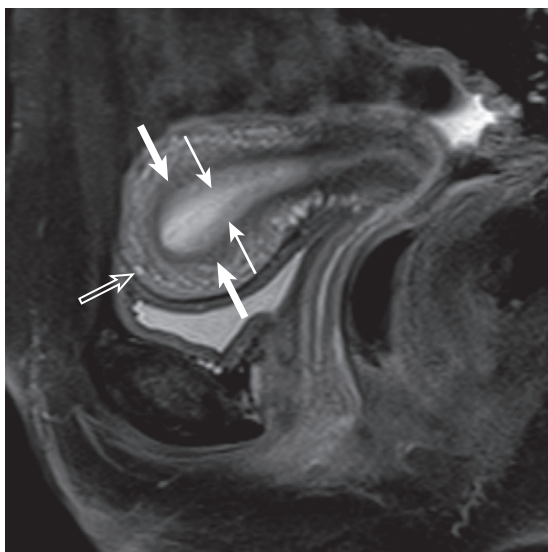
Normal uterine mural stratification. Fat-suppressed sagittal T2-weighted image through the uterus shows the normal trilaminar appearance with the central hyperintense zone (the endometrium—*thin arrows*), the middle hypointense zone (the junctional zone—*thick arrows*), and the outer isointense zone (outer myometrium—*open arrow*).
